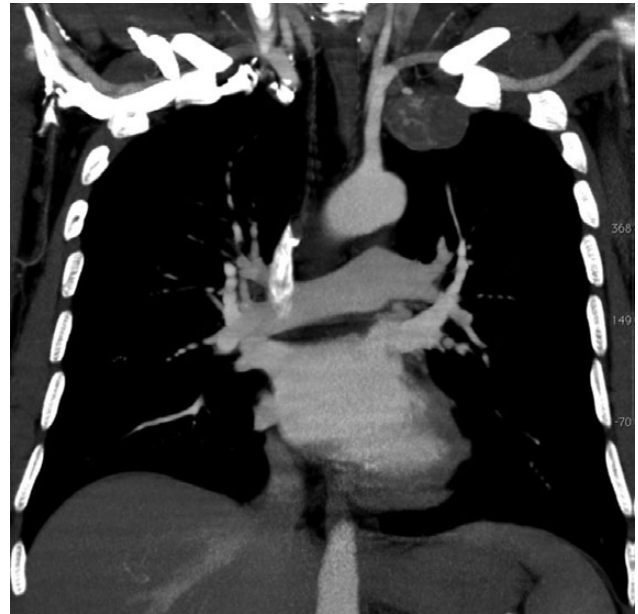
MRI scan of the thorax shows a tumour at the left pleural cupula.
